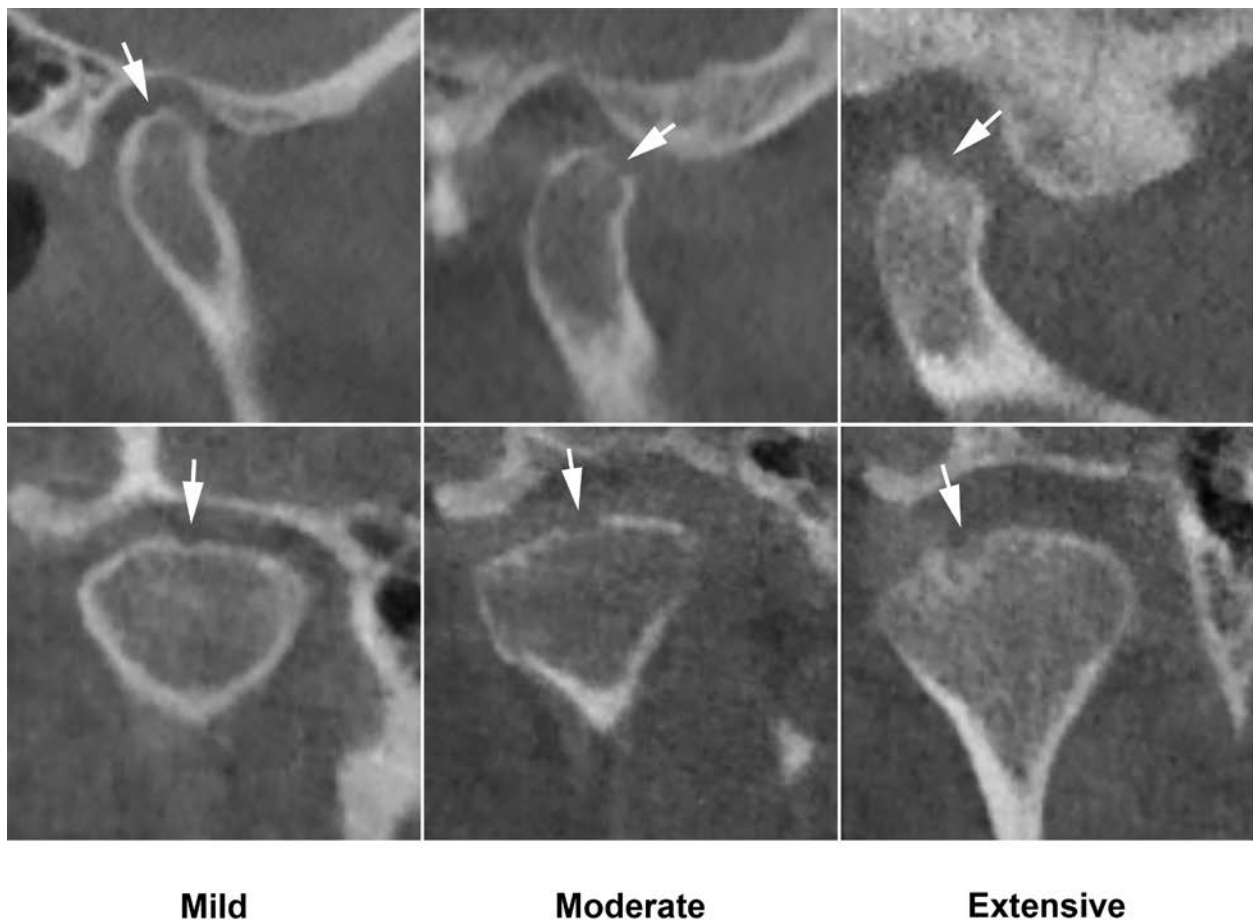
Sagittal (top) and coronal (bottom) CBCT images showing severity scale of condylar erosion
